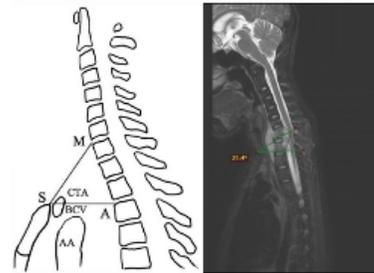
Right: In midsagittal MRI, two lines were drawn from SSN extended horizontally to corresponding anterior border of the vertebrae (SA) and another to midpoint of the anterior border of C7/T1 intervertebral disc (SM). The angle at SSN known as CTA. Figure also shows relation of left BCV and the aortic arch (AA). Left: The CTA measured in this patient was 29.4°.
